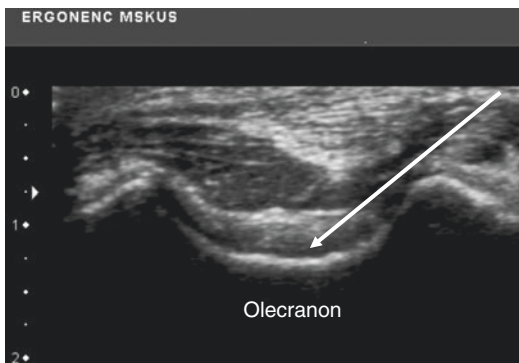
Sonogram of the posterior elbow joint injection with an in-plane approach
